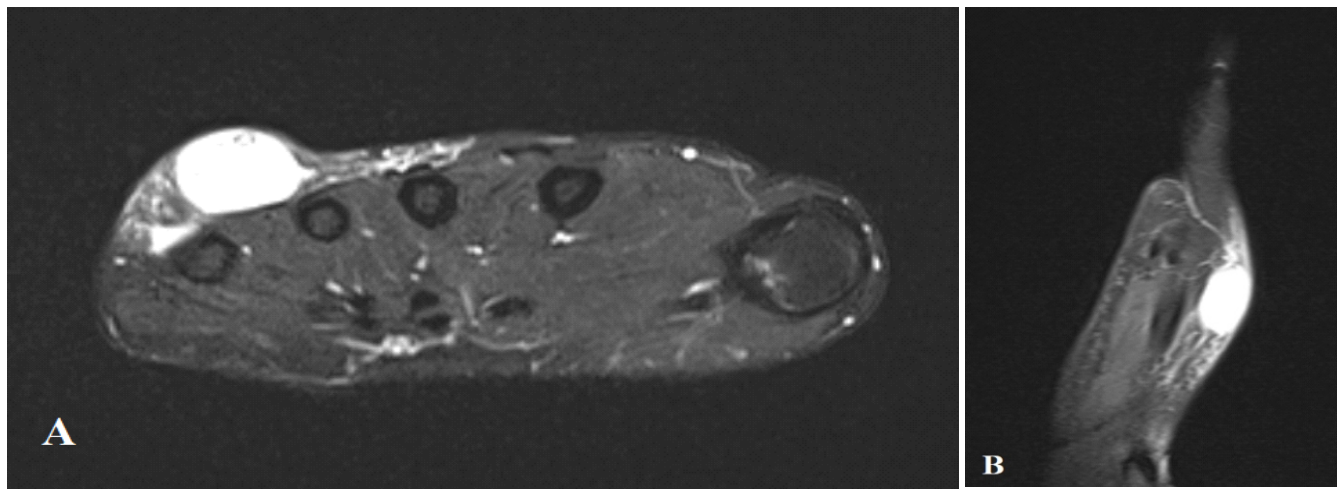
Magnetic resonance imaging T2-weighted images of the dorsal myxoma in axial (a) and sagittal (b) views. It is possible to identify a well-defined nodular lesion of oval morphology, in the subcutaneous fat layer of the dorsomedial aspect of the hand, sensitively at the transition planes of the metacarpal bones. It contacts the surface of the extensor tendons of the 4th and 5th fingers, apparently without involvement.
